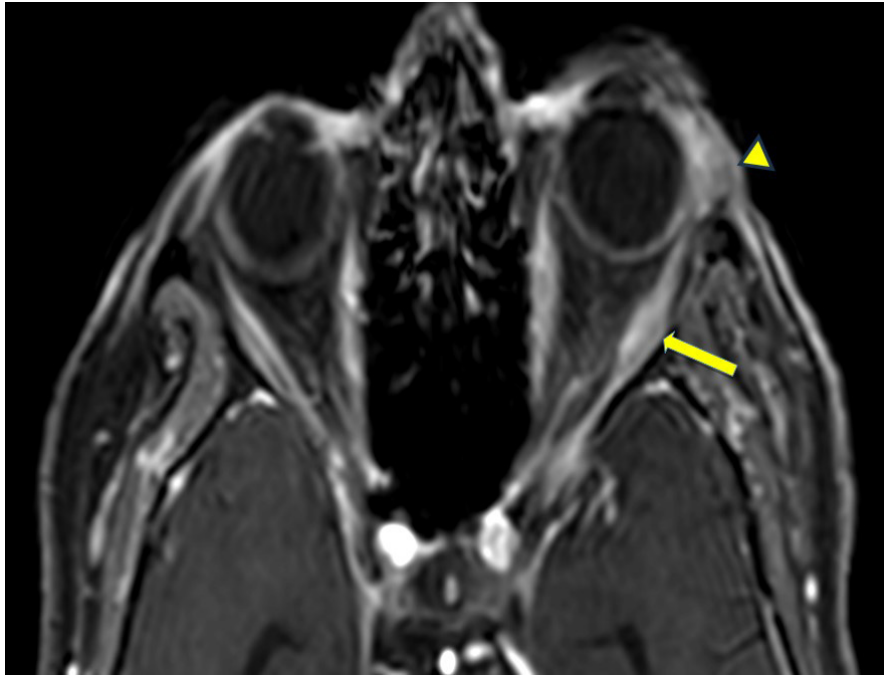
MRI T1 fat saturated postcontrast axial image of both orbits shows thickening and increased enhancement of the left lateral rectus muscle (arrow) along with enhancing pre-septal soft tissue (arrow head).
